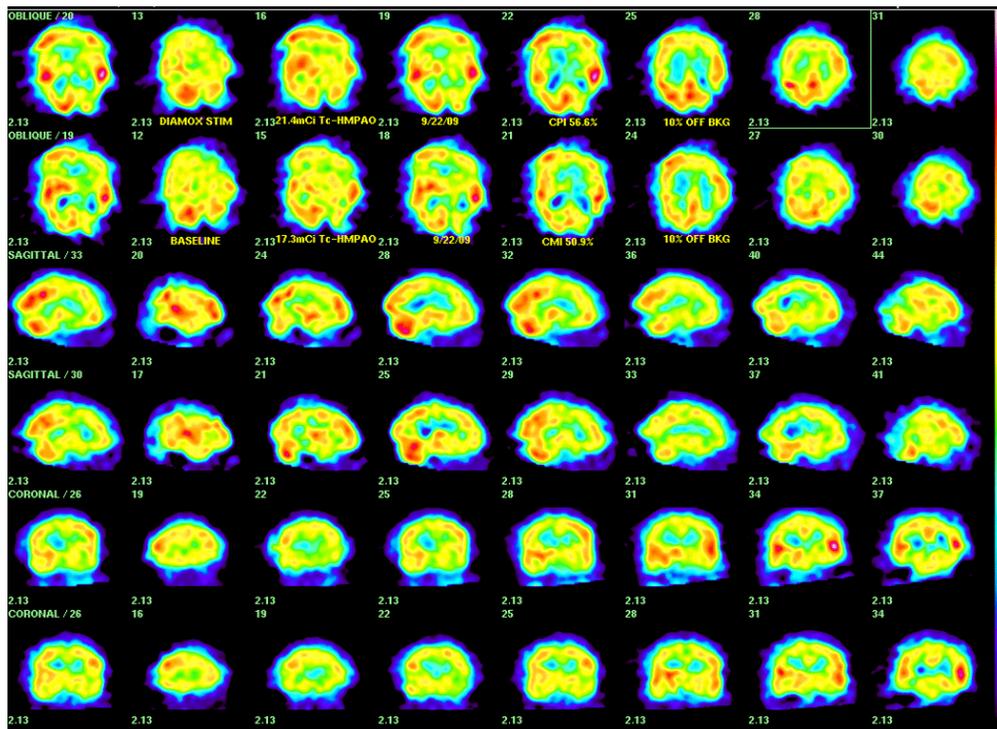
Positive Effect of Incretin Therapy: A 56 year-old hypertensive, type 2 diabetic woman with memory loss (MMSE 26/30; TYM 29/50) had CMi 50.1% and CPi 44.2% (abnormal CFI - 5.9%) on baseline brain SPECT. Follow-up brain SPECT after two years, shown below, shows CMi 50.9% and CPi 56.6% with normal CFI 5.7%, cf. low likelihood of disease patients CFI (6.67±2.83)% after control of hypotension with aliskirin (Tekturna), hyperlipidemia with atorvistatin (Lipitor) and glycemic control (for two years) with exenatide (Byetta). Stroke prophylaxis in this patient was cilostazol 100 mg oral twice daily. Her memory also improved and TYM increased from 29/50 to 34/50.
